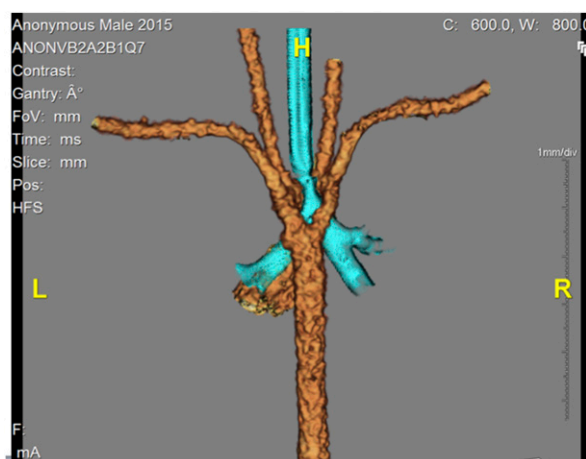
Computed tomography of the chest showing the paired aortic arches encircling the trachea.
